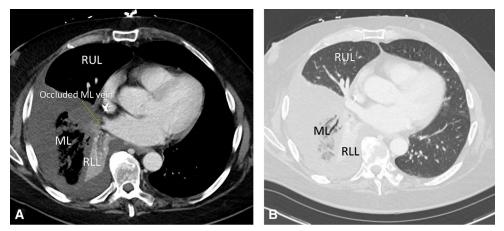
Computed tomography images demonstrating (A) an abruptly occluded middle lobe vein (*arrow*) and (B) ML bronchus with dense consolidation of the ML with hemorrhagic infarction consistent with ML torsion. *RUL*, Right upper lobe; *ML*, middle lobe; *RLL*, right lower lobe.
